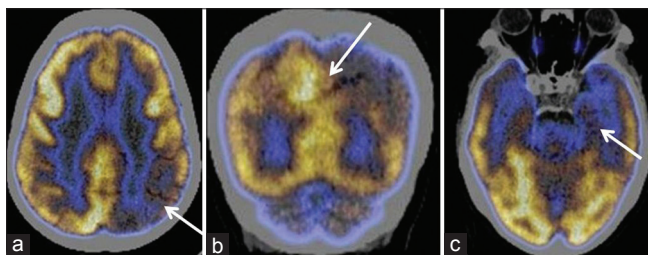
(a) Transaxial fused F-18 fluorodeoxyglucose positron emission tomography/computed tomography images in a case of mild cognitive impairment with mini mental state examination of 25 showing hypometabolism in the left parietal cortices (arrow). (b) Coronal fused FDG-PET/CT image showing hypometabolism in the left precuneus (arrow) and in the left parietal cortex. (c) Transaxial fused FDG-PET/CT images showing hypometabolism in the left mesial temporal cortices
